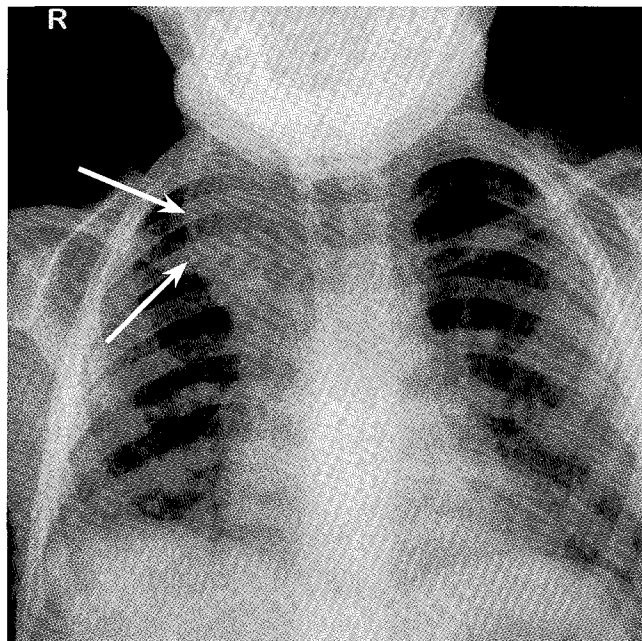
Initial chest radiograph. A density adjacent to the trachea (arrows) merges with the mediastinum widening this structure. Tracheal impression suggests the presence of mediastinal mass.
